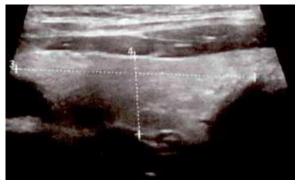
right thyroid lobe of 4.53 by 1.3 cm Figure 2. Thyroid ultrasound on a 53-year old male confirmed with pappilary thyroid cancer and accidentaly
